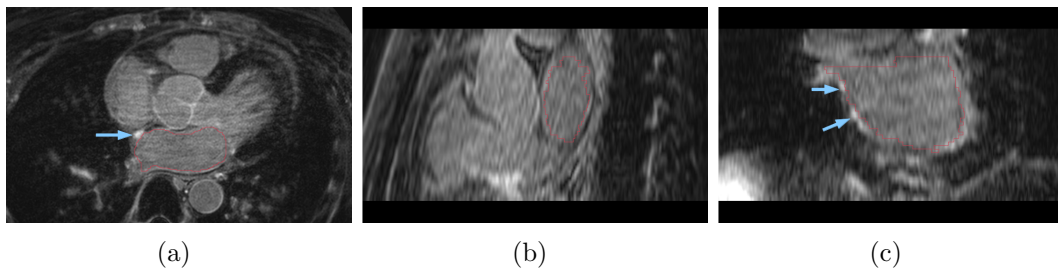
Scar tissue in a DE-MRI image. The LA is highlighted with red contour. From left to right: the scar tissue in axial, sagittal, and coronal views, respectively.
